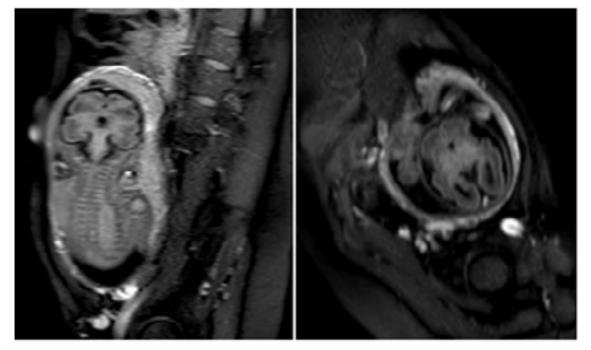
FLAIR sequence: on the left sagittal image; on the right axial
